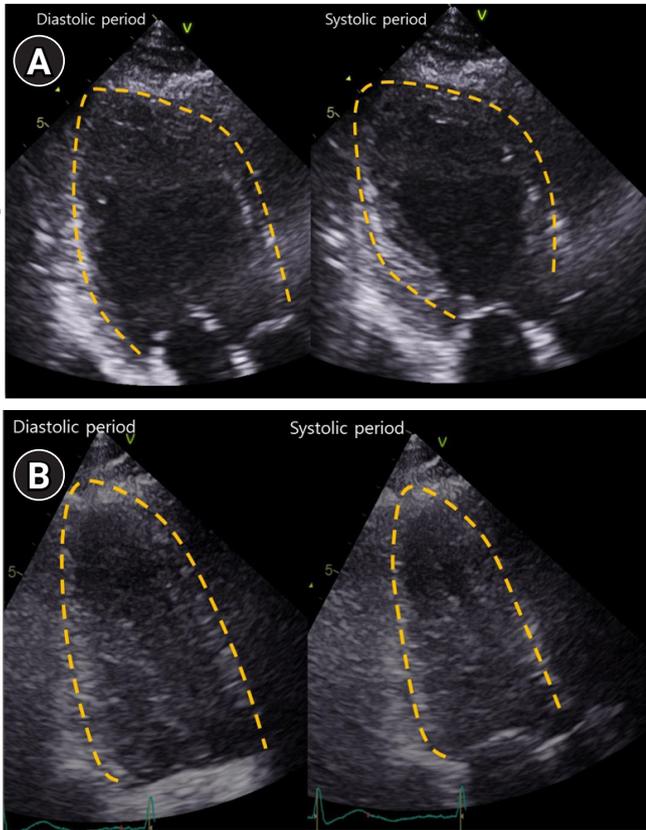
Serial transthoracic echocardiography (TTE). (A) TTE demonstrated severe global hypokinesia of left ventricular (LV) base, akinesia of mid-LV to apex without thinning, and reduced LV systolic function. (B) Repeat TTE showed complete recovery of LV dysfunction.
